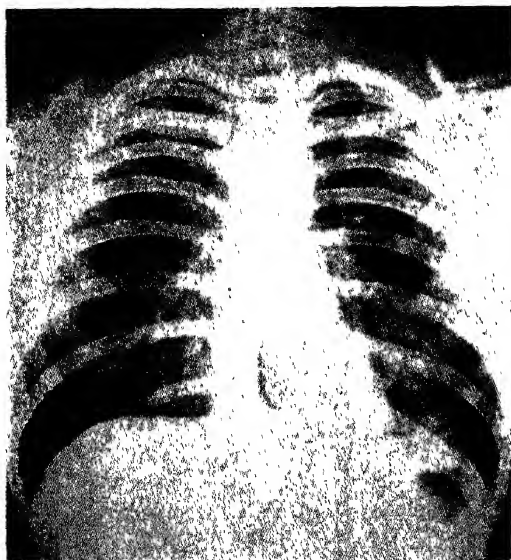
"Cotton-wool" appearance of centrally located early infiltration and partial consolidation. (A. E. Seeds and M. L. Mazer : Am. J. Roentgenol.)
